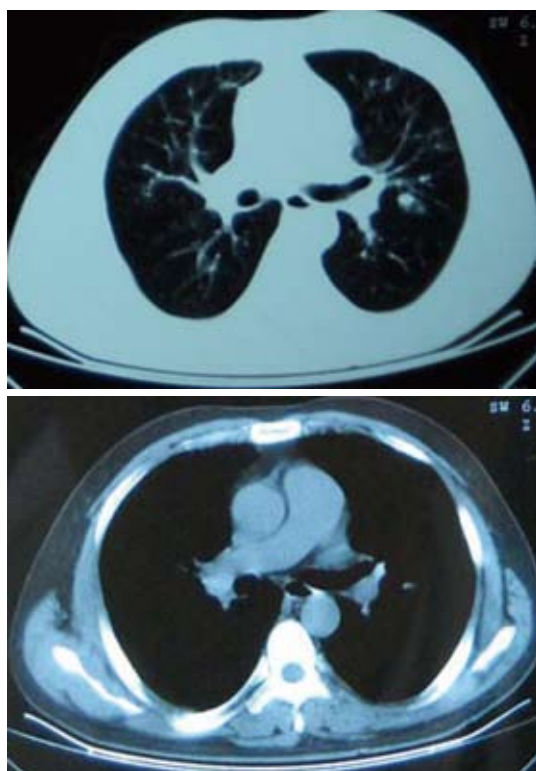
Computed tomography scan of the thorax (April 5, 2009), showing multiple patchy shadows in both lung fields almost disappeared.
